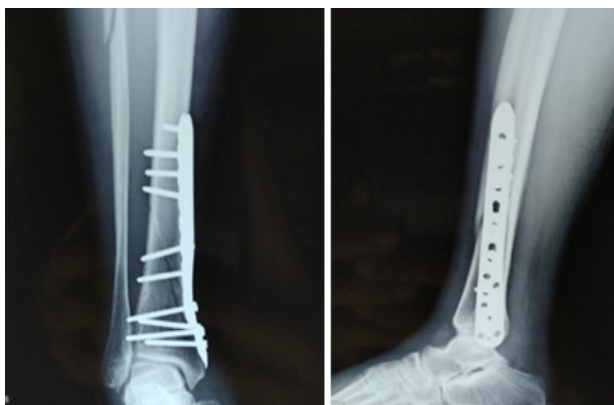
Distal Tibia and Fibula Fracture X-Ray Lateral and AP view
